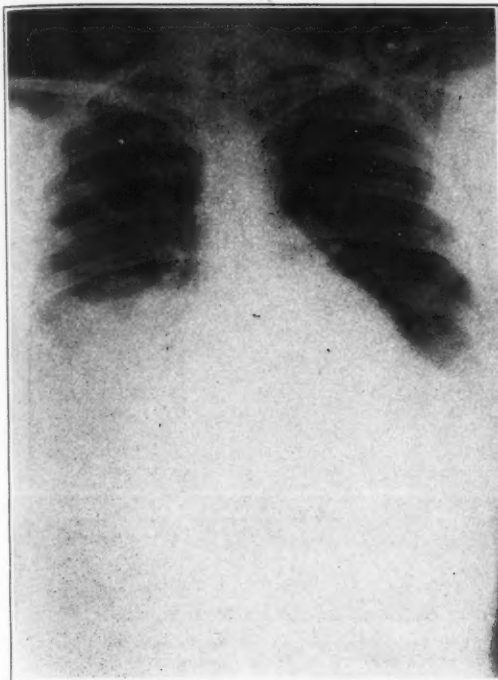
X-ray of lung on December 7, showing abscess in right lower lobe with fluid level.
